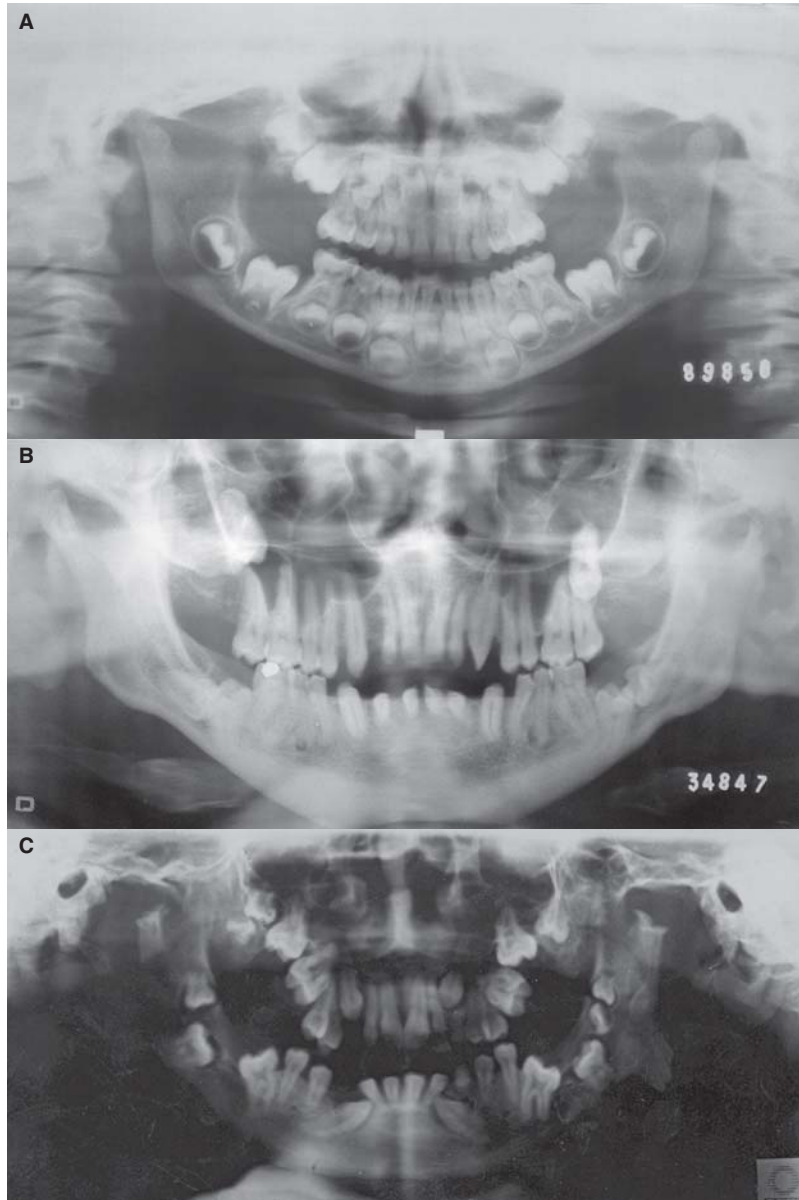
(A) Radiographic findings in patient MPS I (patient no.12). Note the condylar defect and flat mandibular notch. (B) Radiographic findings in patient MPS II (patient no.2): Delay/retention eruption, short mandibular ramus, wide mandibular base, irregular bone cortex, malformed glenoid cavity and condylar defect, flat mandibular notch, wide coronoid process, ectopic teeth and impacted teeth. (C) Radiographic findings in patient MPS VI (patient no.3): Delay/retention eruption, delay in root formation, short mandibular ramus, wide mandibular base, condylar defect, thickness of dental follicle, ectopic teeth, impacted teeth and supernumerary.
